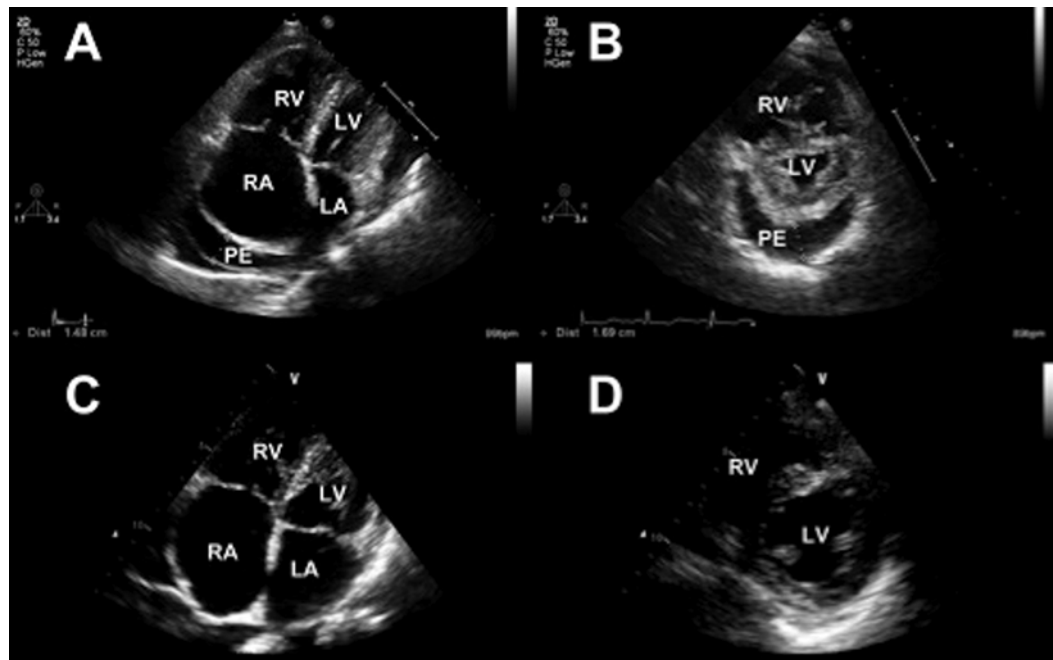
Echocardiographic images showing resolution of pericardial effusion in a patient with pulmonary arterial hypertension before epoprostenol therapy (A and B) and after a year of epoprostenol therapy (C and D). LA: left atrium; LV: left ventricle; PE: pericardial effusion; RA: right atrium; RV: right ventricle. A color version of this figure is available in the online edition.
